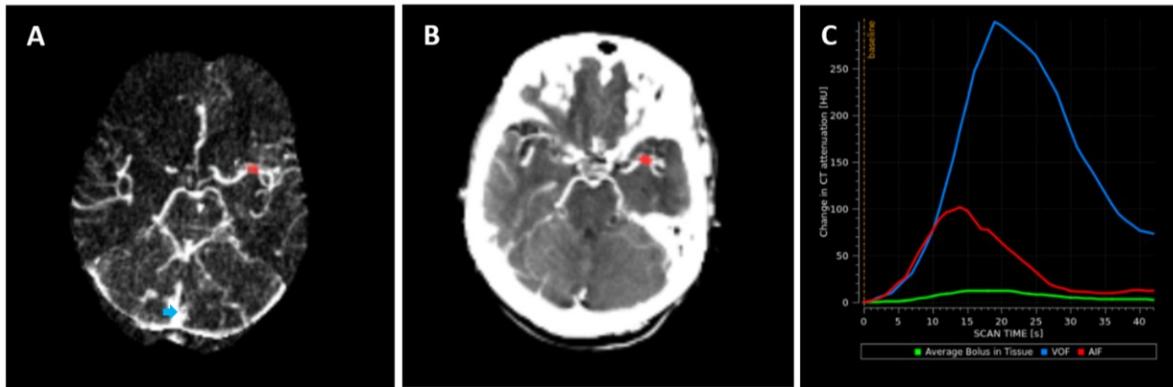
CT perfusion inputs and curves. A: Venous output (blue), B: Arterial input (red), C: Arterial (red) and venous (blue) graphs and tissue bolus (green)-appropriate curves.
